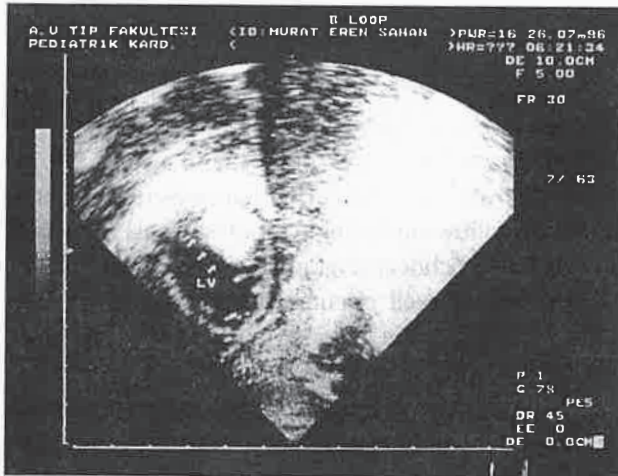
Subcostal short-axis echocardiogram from patient showing a 25x15 mm mass (arrows) within the cavity of the left ventricle (LV)
